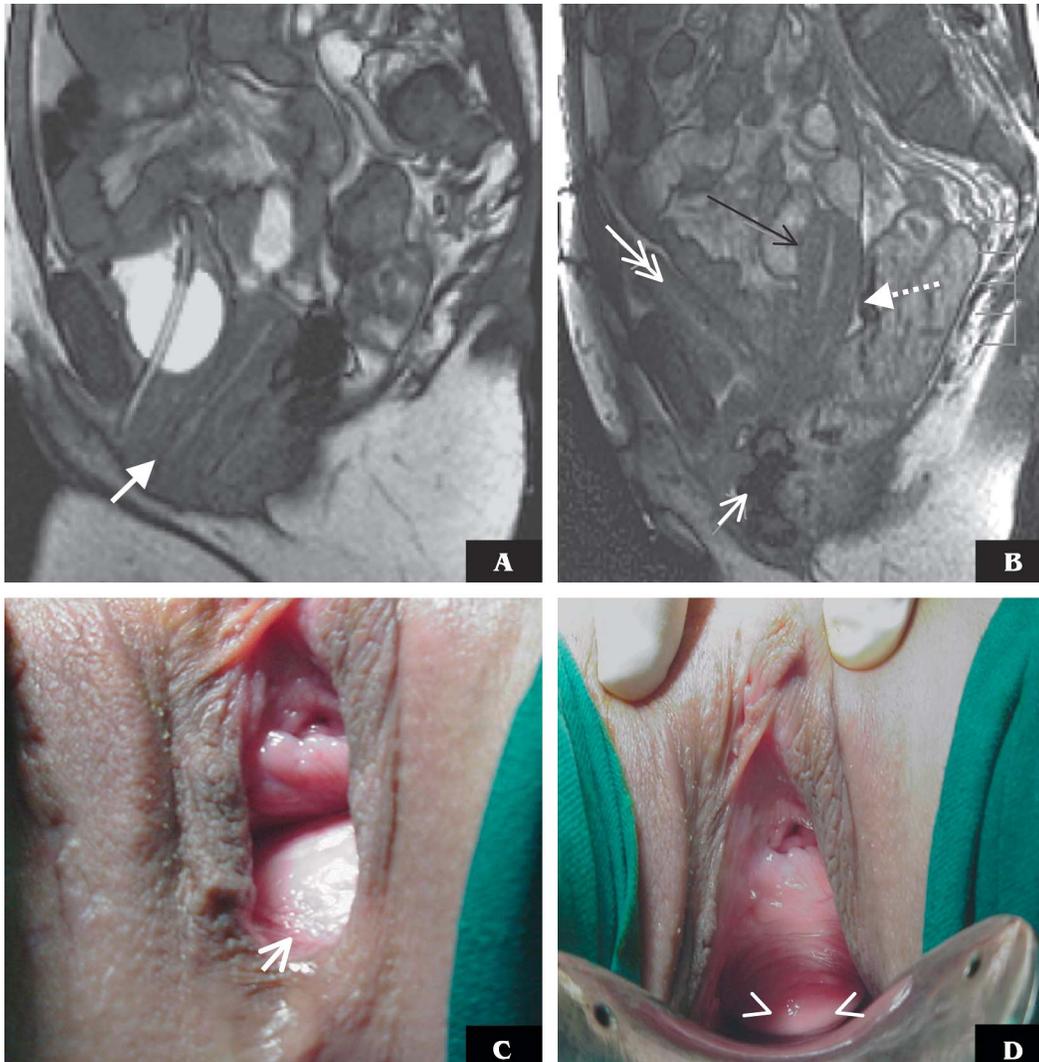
Multi-compartment pelvic floor dysfunction in an 18-year-old woman who suffered trauma during a car accident. A, Sagittal balanced fast field echo MR image (5/1.6 [repetition time (ms)/echo time (ms)]) obtained at strain shows significant descent of the uterus (arrow) below the bladder base (arrow). A catheter identifies the high signal urine-filled bladder. B, Following sacrocolpopexy, repeat MR at strain using the same pulse sequence as in A shows development of a rectocele (short arrow), as reduction of the rectocele was likely achieved at least in part by compression of the adjacent uterus. MRI finding of widened upper part of the rectovaginal space (dashed arrow) suggested rectovaginal fascial tear. The uterus is now in the appropriate position (long arrow), urinary bladder (double headed arrow). C, D, Photograph of the pelvic floor with patient in lithotomy position (during follow-up examinations after sacrocolpopexy) show bulging of an anterior rectocele (arrow) (C), and a sigmoidocele was noted (arrow heads) (D) after reduction of the rectocele, corroborating findings of MRI.
